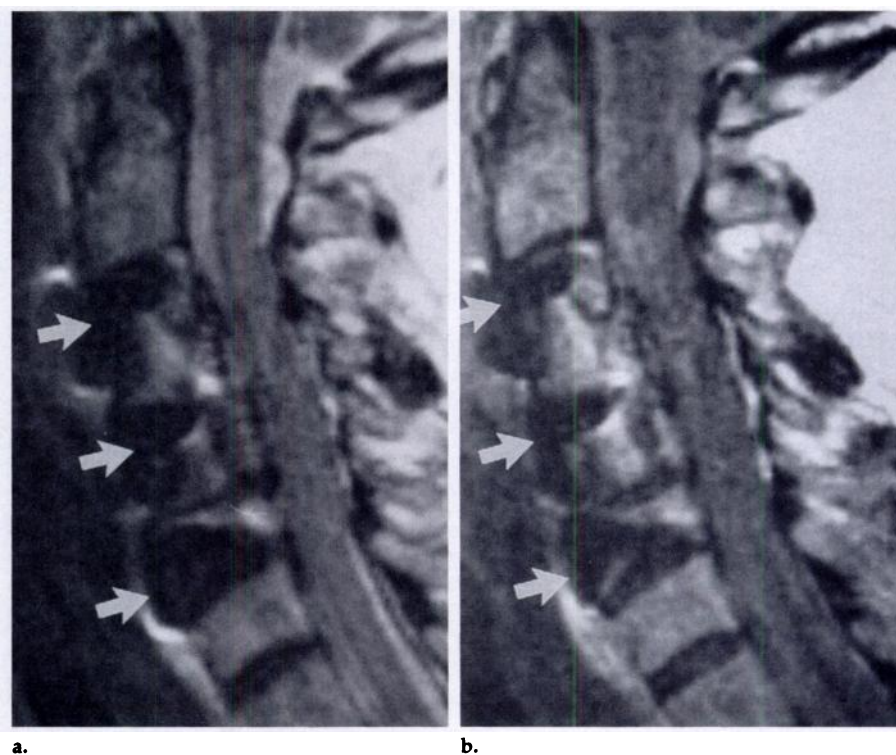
Effect of varying echo spacing on degree of artifact reduction. (a) Sagittal T2-weighted FSE image (2,000/85, two signals averaged, echo train length = eight, echo space = 17 msec) of the cervical spine in a patient with anterior fusion plate and screws from C-3 to C-5 shows moderate artifact over the vertebral bodies (arrows). (b) Sagittal T2-weighted FSE image (2,000/88, two signals averaged, echo train length = eight, echo space = 11 msec) obtained at the same location as a shows decreased artifact (arrows). Note that noise increased as a result of the higher receive bandwidth that was required to obtain the shorter echo spacing.
